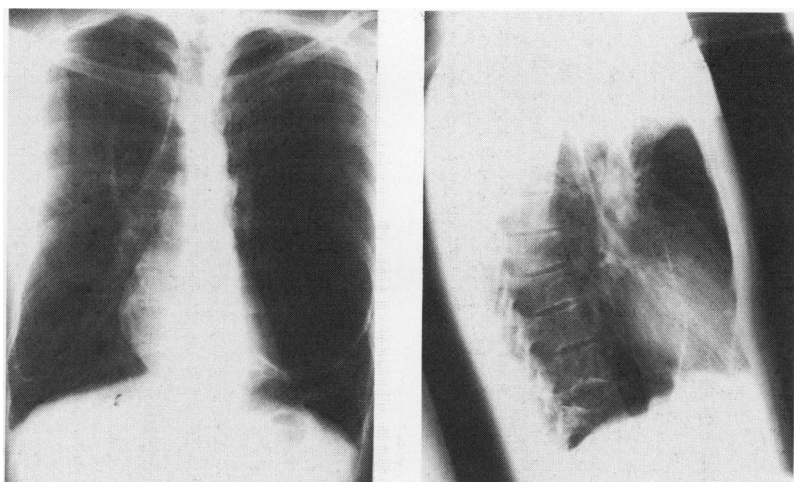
Chest radiograph showing a large cystic lesion occupying almost the entire left hemithorax displacing the trachea and mediastinum to the right.
